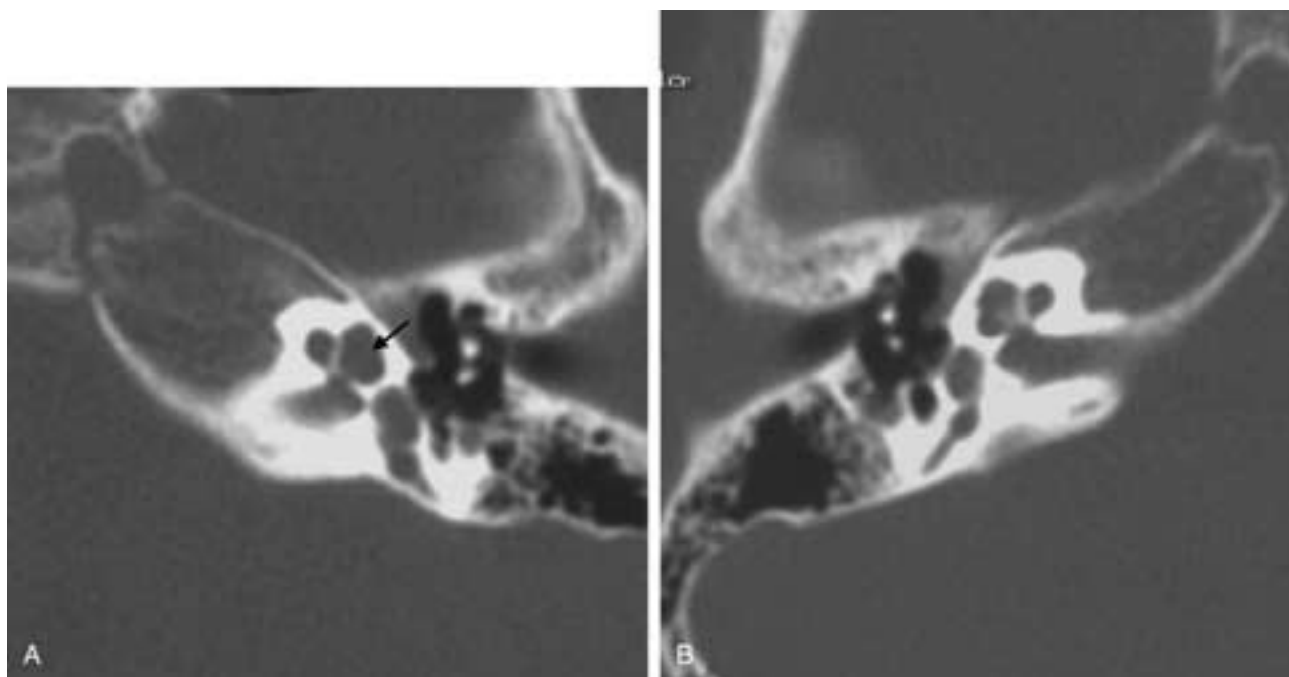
Modiolar deficiency. A, Axial CT image showing a deficient modiolus with incomplete separation of the second and third cochlear turns on the left (black arrow). B, Axial CT image of the right ear showing a normal bony modiolus with normal separation of the cochlear turns.
